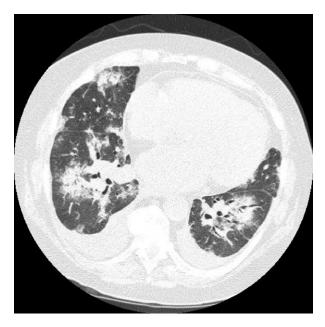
CT scan of BOOP. Consolidation/nodules are shown.
